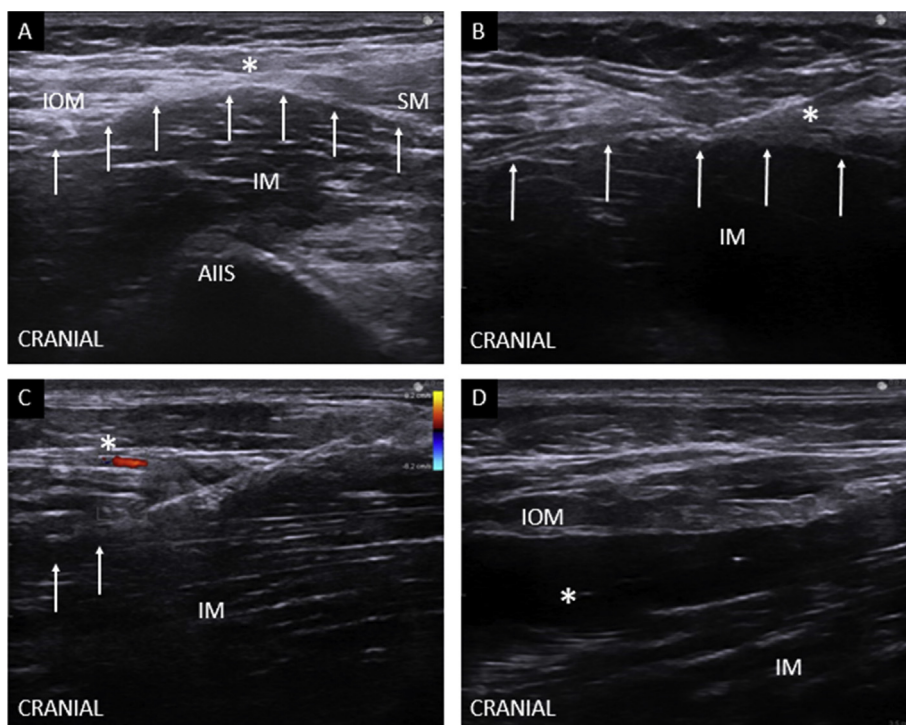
Ultrasound landmarks and injection for supra-inguinal FICB. A) IOM: Internal oblique muscle, SM: Sartorius muscle, AIIIS: Anterior inferior iliac spine, IM: Iliacus muscle, White asterisk: Bow tie sign of iliac fascia, White arrows: Iliac fascia. B) IM: Iliac muscle, White asterisk: needle. C) IM: Iliac muscle, White asterisk: Deep circumflex artery, White arrows: injection of LA. D) IOM: Internal oblique muscle, IM: Iliac muscle, White asterisk: LA.
